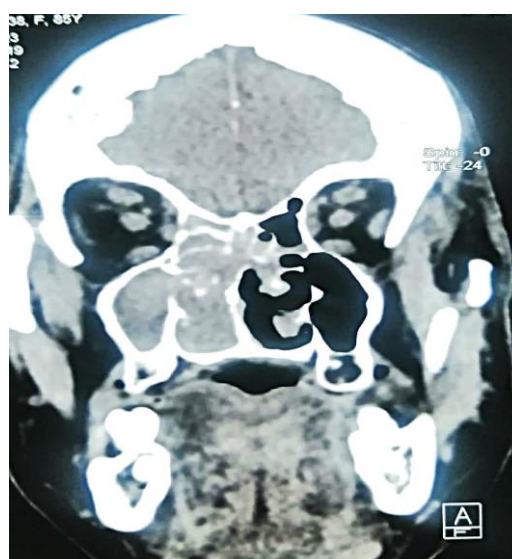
Preoperative coronal sinus CT scan showing a right nasal polypoidal lesion with implant base originating from the olfactory clefts
